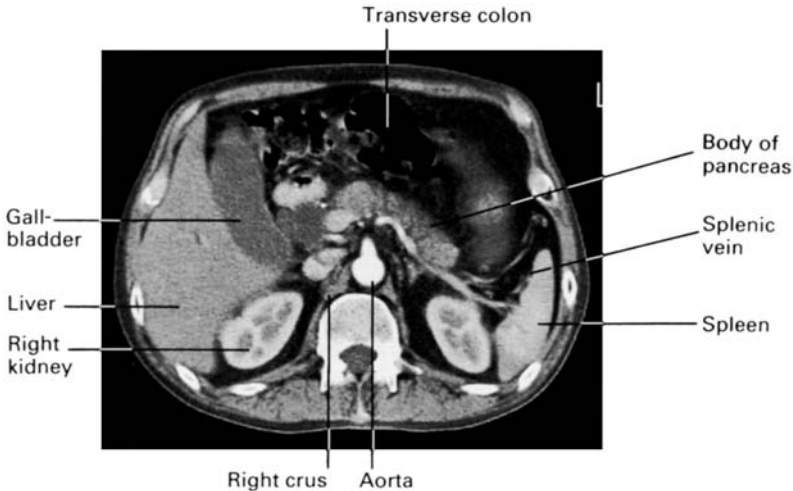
CT scan at the level of the 1st lumbar vertebra. This demonstrates the liver, gall-bladder, aorta with the commencement of the superior mesenteric artery, the inferior vena cava, the crura of the diaphragm, the kidneys, pancreas and the spleen. The splenic vein can be seen as it passes to the splenic hilum posterior to the body of the pancreas. The vena cava lies on the right crus. The vessels have been enhanced by an intravenous injection of contrast.
